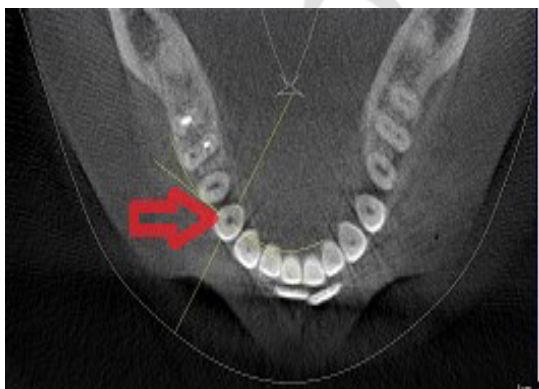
CBCT of mandible first premolar; axial plane, Type I canal configuration
